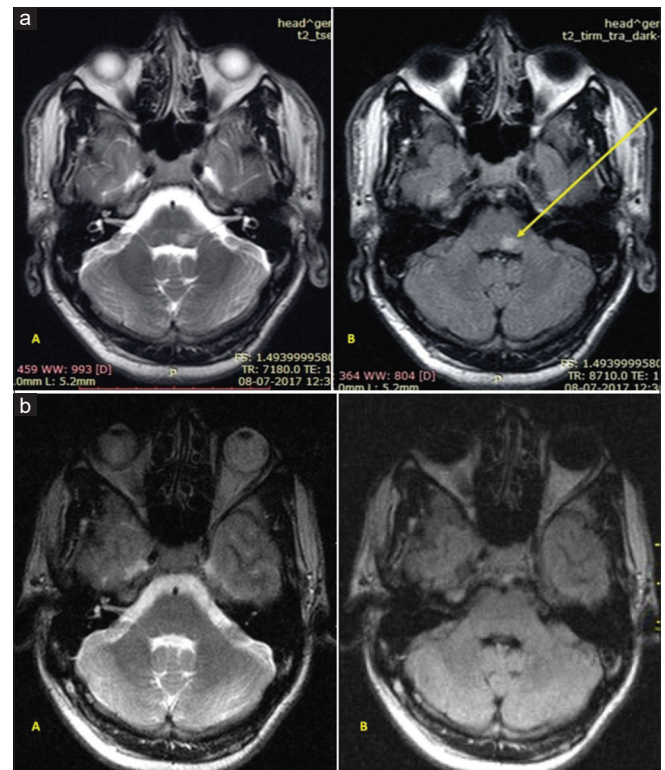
(a) MRI of the brain Axial T2 and FLAIR images showing a focal hyperintense lesion in the dorsal aspect of left pontomedullary junction (yellow arrow). (b) Repeat MRI of the brain Axial T2 and FLAIR image showing complete resolution of the previous lesion
